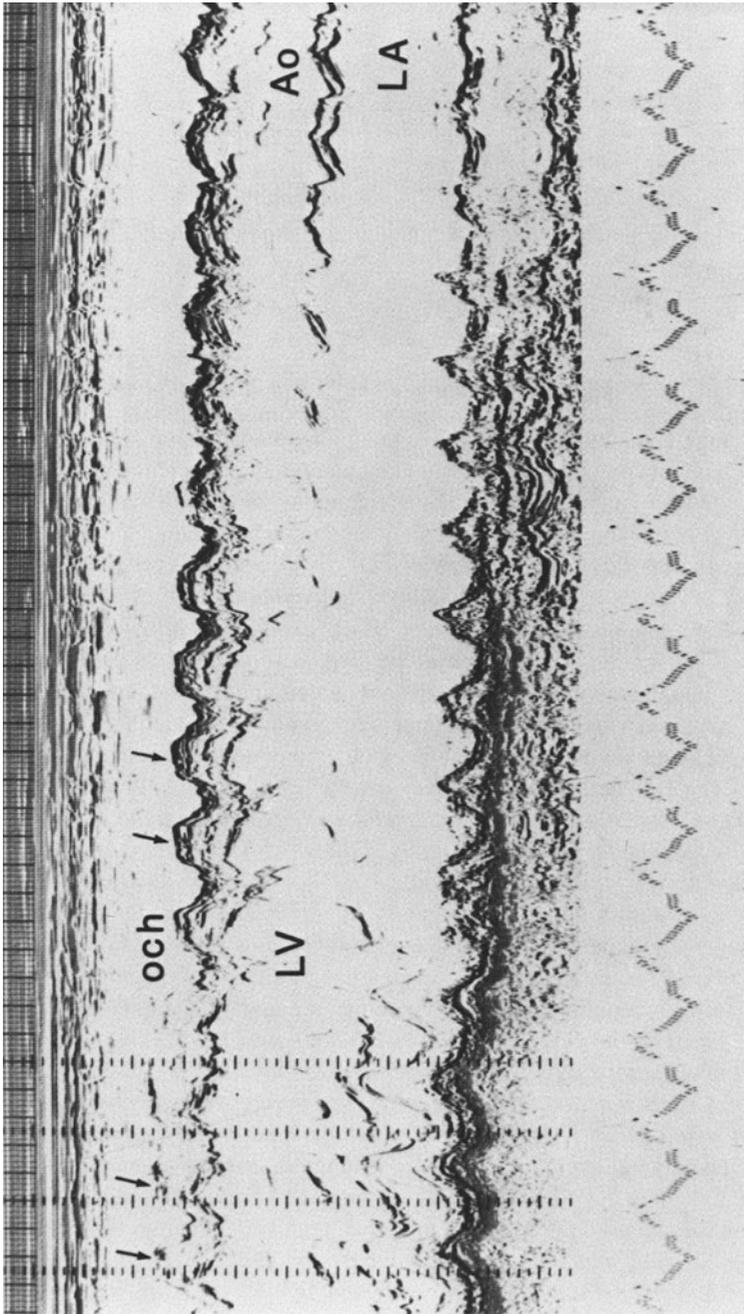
M-mode echocardiogram showing paradoxical septal motion (arrows) in a post-Fontan patient in whom an uncomplicated atrioventricular conduit was present. (Ao, aorta; LA, left atrium; LV, left ventricle; och, outlet chamber, right ventricle.)
